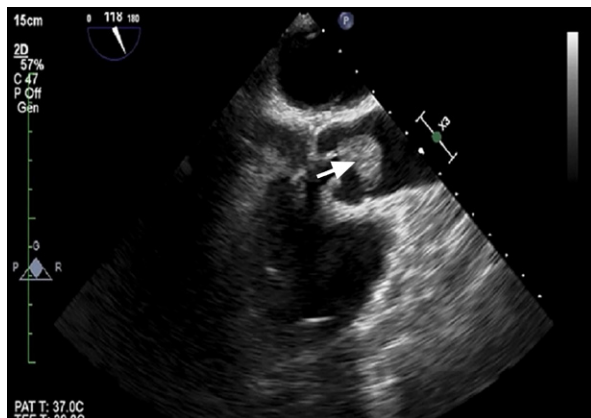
Transesophageal echocardiogram shows a 2 × 2-cm immobile mass (arrow) arising from the noncoronary cusp of the aortic valve.
